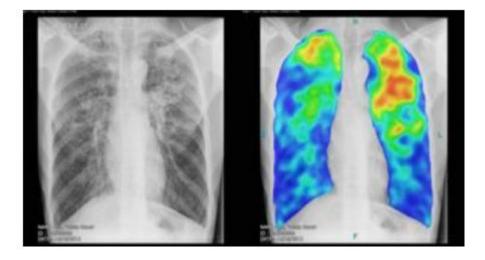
Digital chest X-ray. The left image is for digital chest X-ray. The right image is for CAD4TB analysis (specific software analyzes the images to detect any lung abnormalities) of the image. Both images show lung abnormalities. Retrieved from [24].
